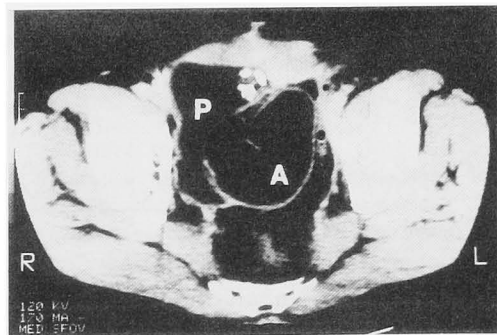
Stenosis at afferent limb. CT revealed two cavities; P: pouch, A: the dilated afferent limb.
